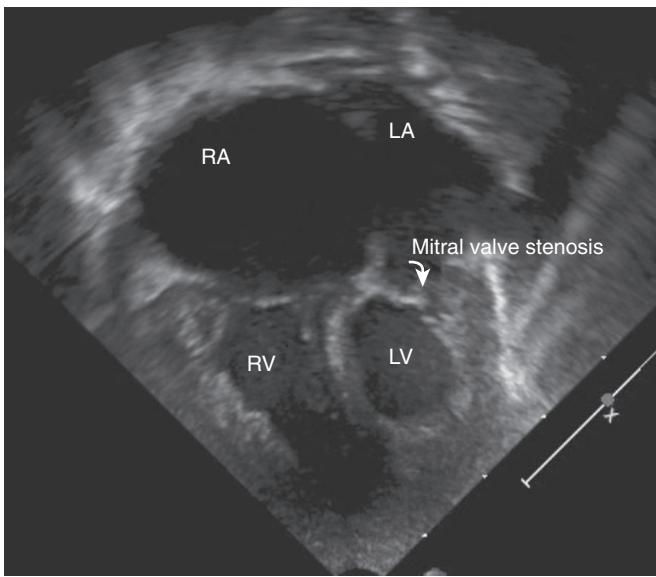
Apical four-chamber view on echocardiogram of a neonate with diminished pulses and poor perfusion. There is mitral valve stenosis with severely hypoplastic left ventricle (LV) and marked size discrepancy compared to the right ventricle (RV), consistent with hypoplastic left heart syndrome. LA, Left atrium; RA, right atrium.
